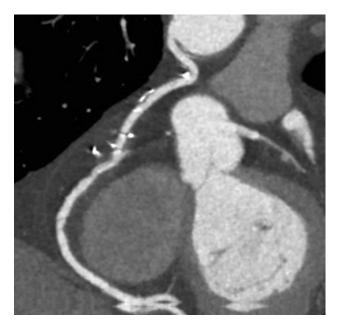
Three-dimensional volume rendering of a computed tomographic image obtained 6 years postoperatively confirmed a patent left radial artery bypass.
